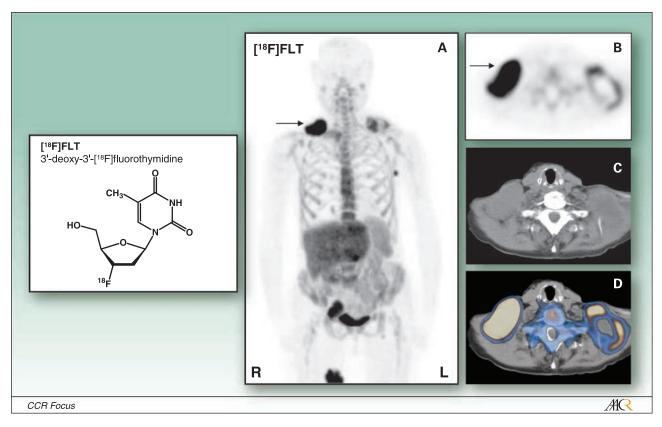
[¹⁸F]FLT. [¹⁸F]FLT. [¹⁸F]FLT-PET/CT of a patient with aggressive non – Hodgkin's lymphoma. Intense focal tracer uptake can be observed in sites of lymphoma involvement, including sites at the right supraclavicular region, left axilla, and right femoral region. Medium intense uptake in the tumor margin of a lesion at the left shoulder region.
